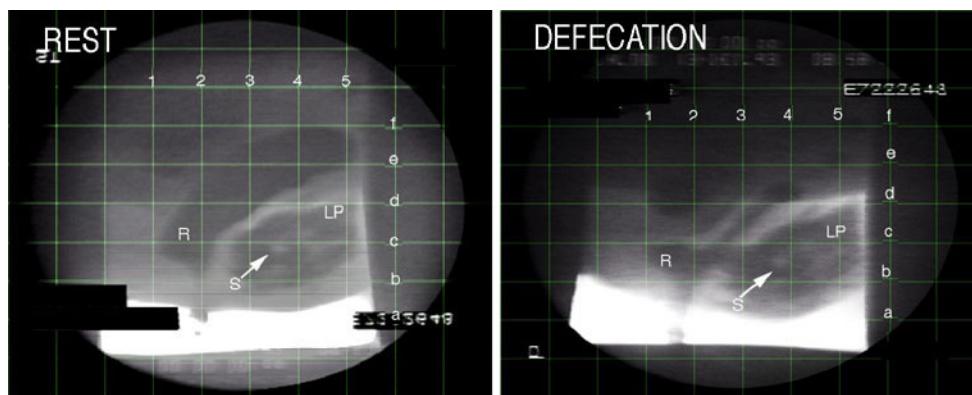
Video X-ray of rectum (R) and LP. Fecal incontinence. At Rest Patient in sitting position. The white oval (S) inside the LP muscle (LP) is a natural space. The superior surface of the LP is almost horizontal. The ARA is approximately 120 degrees. During defecation The posterior ARA has been pulled open posteriorly by the apparent attachment of LP into the posterior wall of the rectum and has moved downwards to lie between lines c, b. The ARA is now
